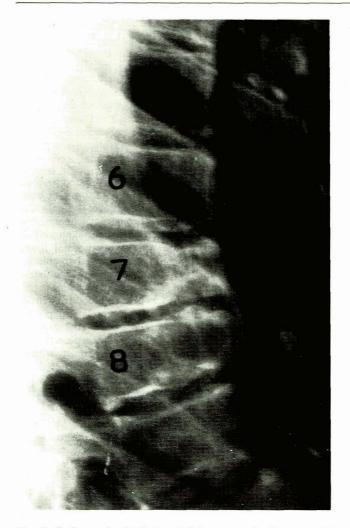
Radiograph of advanced Scheuermann's disease, with characteristic structural changes, and anterior wedging at T7 and T8 levels.
